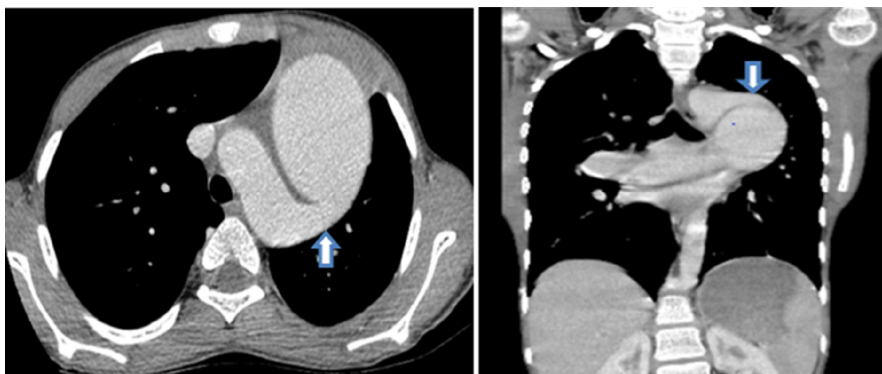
Axial CT pulmonary angiography showing dilated main pulmonary artery (MPA), right (Rt PA) and left (Lt PA) pulmonary arteries.
